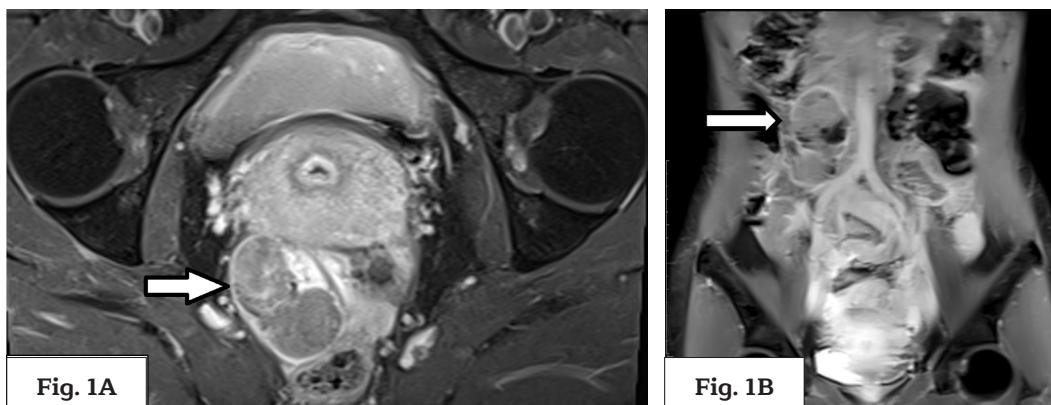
MRI images of lower abdomen revealed a $6.1 \times 3.0 \times 4.2 \text{ cm}$ heterogeneous enhancing mass at right adnexa abutting to right uterus, urinary bladder, and upper rectum without definite invasion (figure 1A). The image of upper abdomen showed a $4.5 \times 4.0 \times 8.4 \text{ cm}$ lobulated mass with internal cystic portions compressing on inferior vena cava without fat plane (figure 1B).
